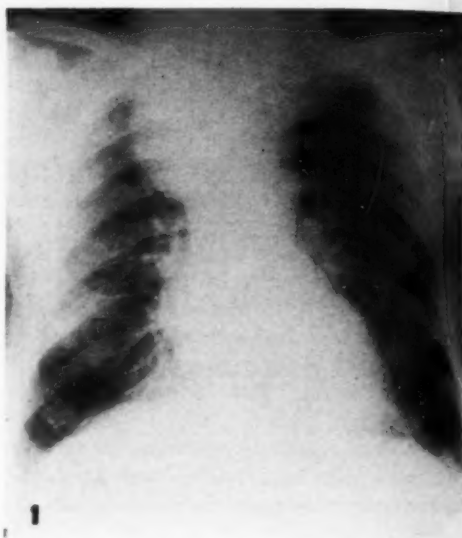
Conventional chest roentgenogram, showing large globular soft-tissue mass in right superior mediastinum and displacement of trachea to left.
